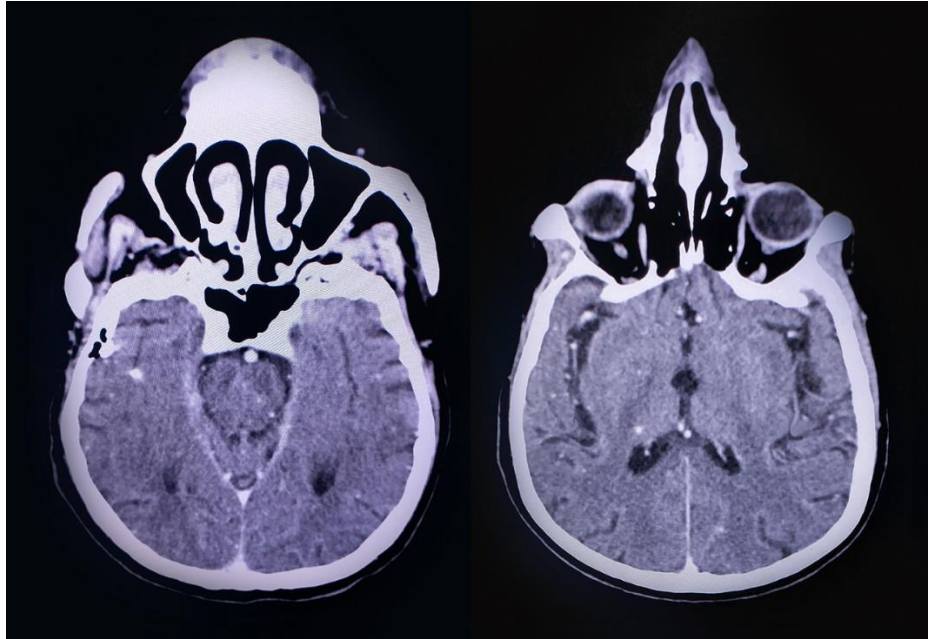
Computed tomography scan, multiple calcifications are registered.
